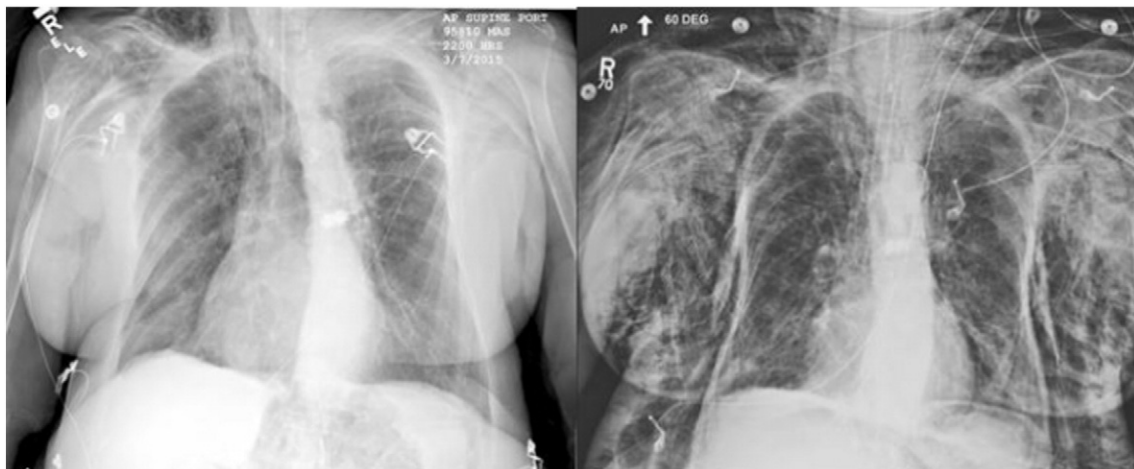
Chest x-ray obtained in emergency department and a few moments after. Extensive subcutaneous emphysema is noted with evidence of pneumomediastinum in the latter image. Lungs appear hyperinflated with changes consistent with severe chronic obstructive pulmonary disease. No pneumothorax was appreciated.
